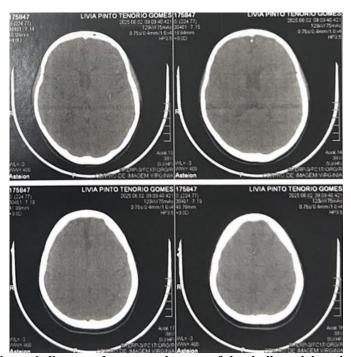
Computed tomography scan of the skull – axial section.
